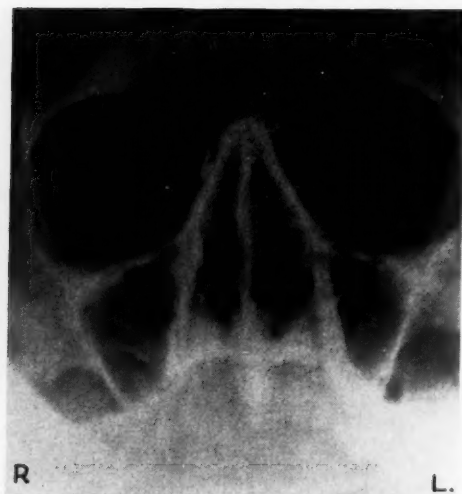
Roentgenogram showing tantalum foil in place. This foil is attached at the upper end by tantalum wire to the orbital periosteum. The irregular outline is due to the fact that the sheet of tantalum is seen edge on. The foil extends downward through the area formerly occupied by the anterior ethmoid cells into the upper part of the nasal fossa.
